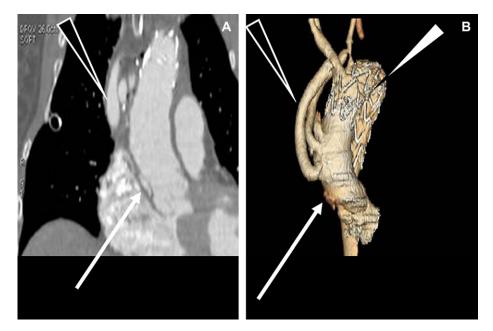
Saggital (A) and 3-D reconstructed (B) CT images following EVAR. The trifurcating supra-aortic bypass is shown (black filled triangle) together with the stent deployed into zone 0-1 (white triangle). The white arrows demonstrate a proximal aortic dissection initially attributed to the patch implantation of the trifurcating patch graft.
